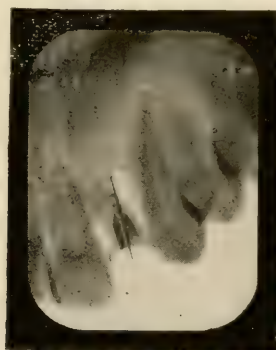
Same as Fig. 432. Radiograph not distorted. See wire passing through side of root to the distal.
